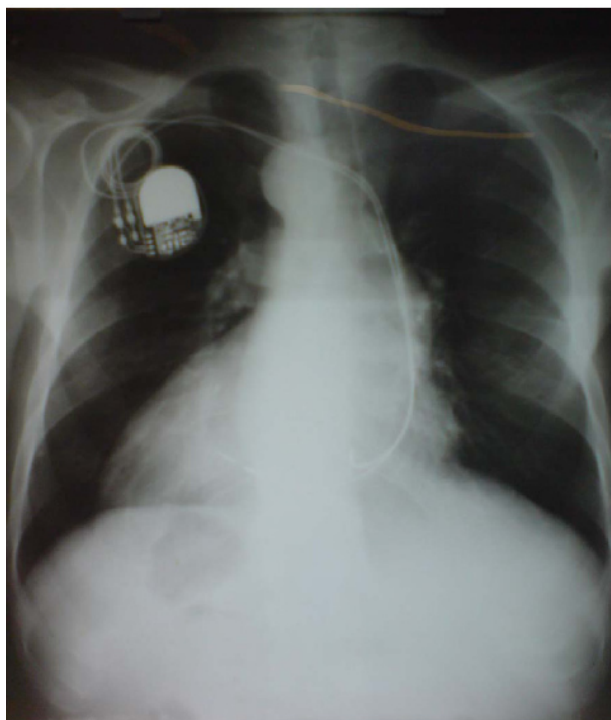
Chest radiography showing dextrocardia, cardiomegaly, right sub-phrenic gastric bubble, and permanent pacemaker.
